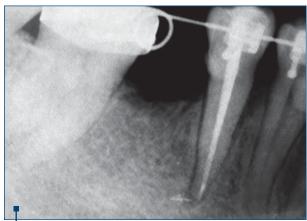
Tooth 45 – postoperative radiograph, with root canal filling
